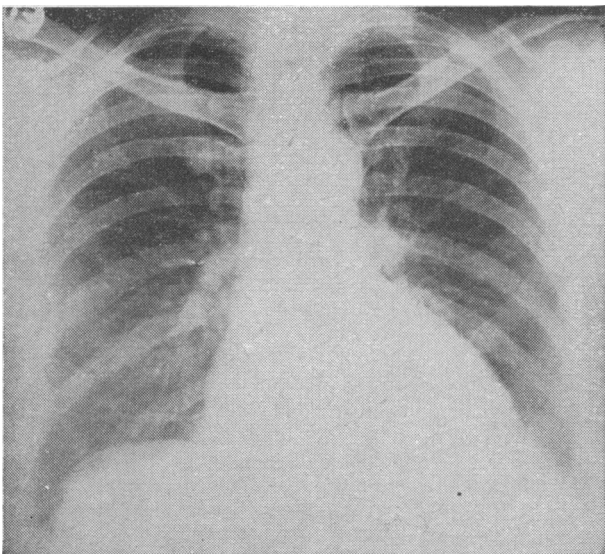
Case 1. Radiograph of chest showing size of heart two years prior to admission.
